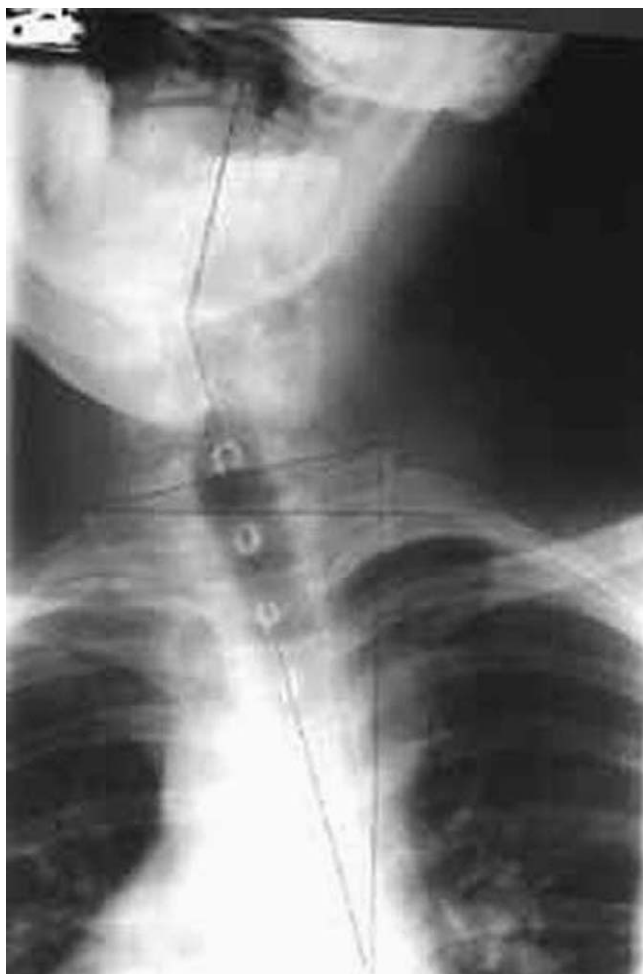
AP radiograph showing lateral deviation of the patient's head and neck.
